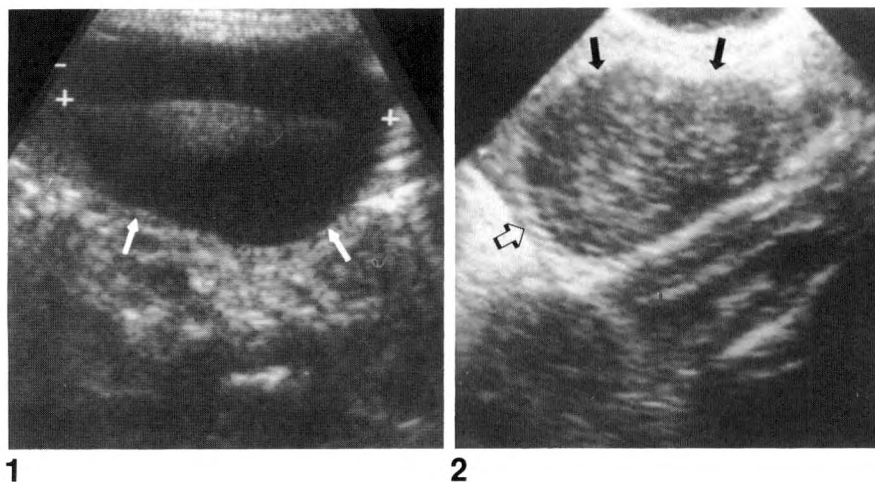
Transverse sonogram, left pelvis. Female neonate with cystic mass (arrows). Few internal echoes are artifacts related to gain setting. Repeat sonograms showed a decrease in size of presumed ovarian cyst and complete resolution at 4 months of age.
